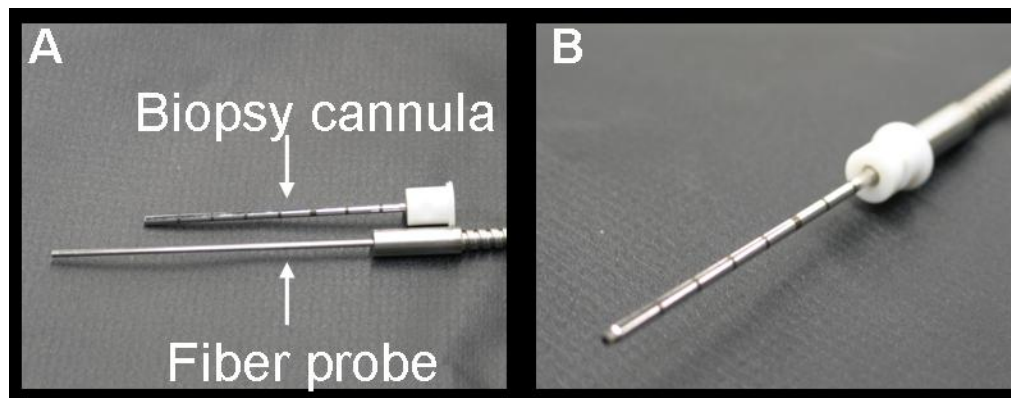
Photographs of A) the custom 14G optical spectroscopy probe and a Bard Vacora biopsy cannula, and B) the probe inserted into the cannula. In our protocol, the cannula will be placed into the tumor under ultrasound guidance, which will provide a means to interface the spectroscopy probe with the tumor in vivo.
